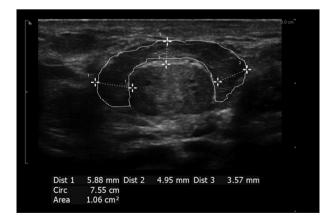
With B Mode ultrasound, using a linear array high frequency transducer, the transverse image of the BCM was identified and the perimeter was outlined by freehand on a static image. BCM, bulbocavernosus muscle.
